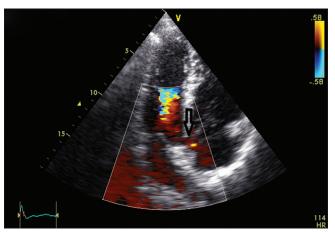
The transthoracic echo cardio performed show an abnormal blood flow between the left ventricle and the right atrium (arrow)
